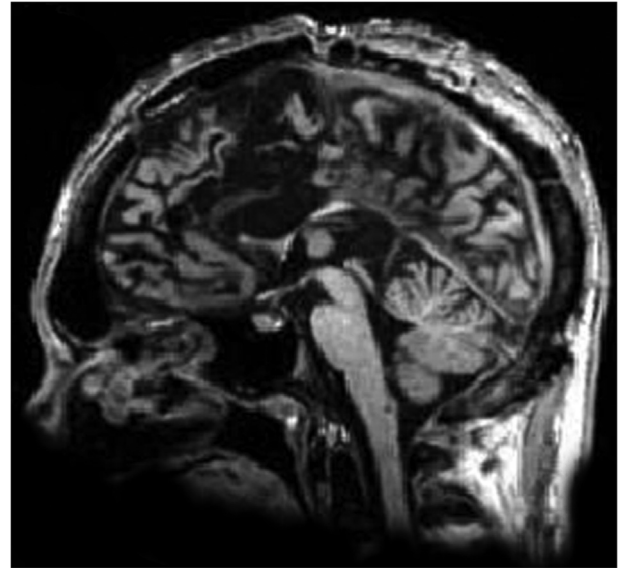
Midsagittal MRI of patient D.D.C., showing the complete absence of callosal fibers.
